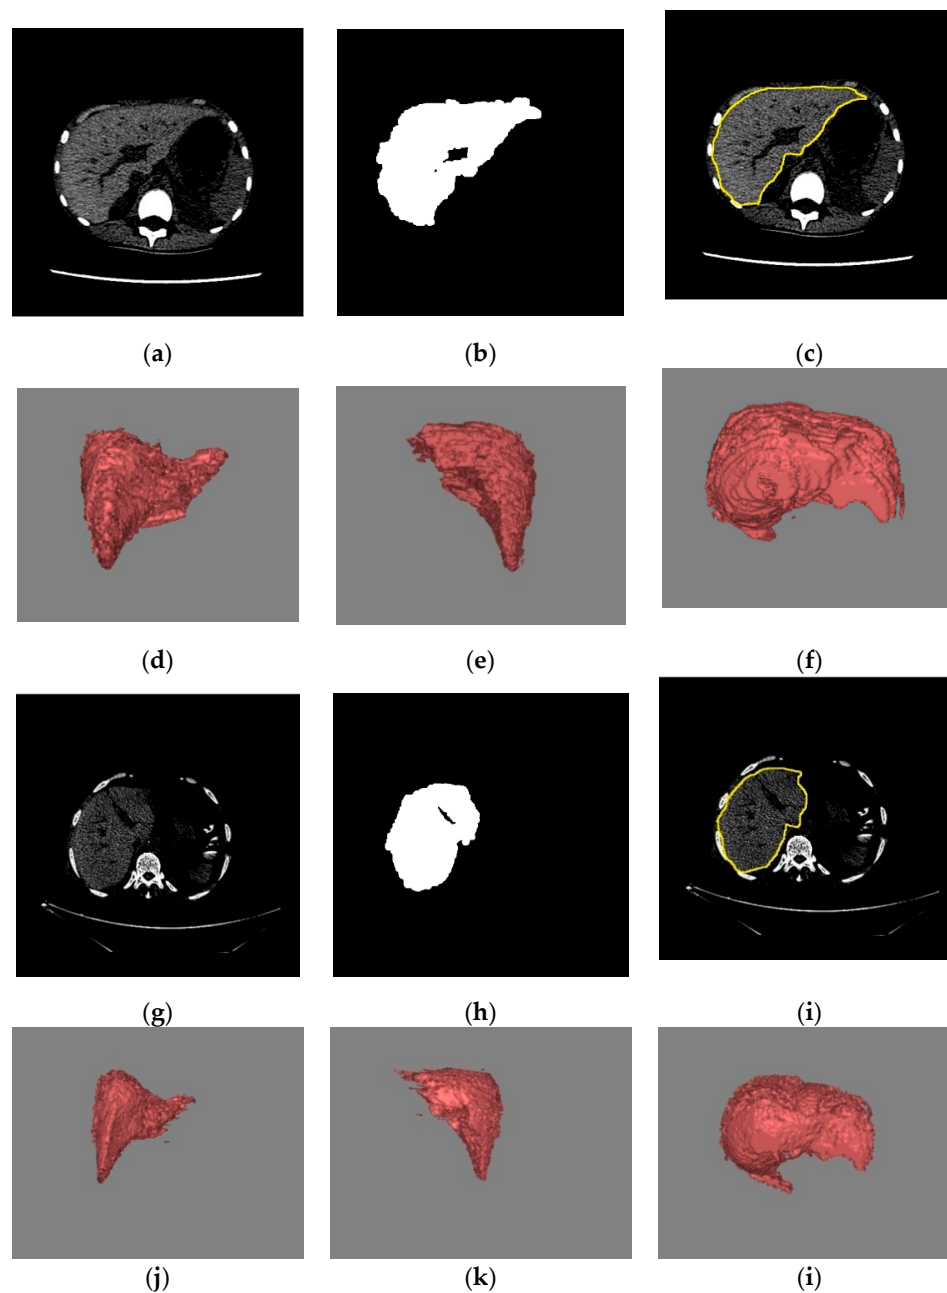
(a,g) Raw clinical CT slice; (b,h) segmented CT slice; (c,i) referential boundary detection; volume extraction of liver in (d,j) bottom view; (e,k) straight view; (f,l) top view.
